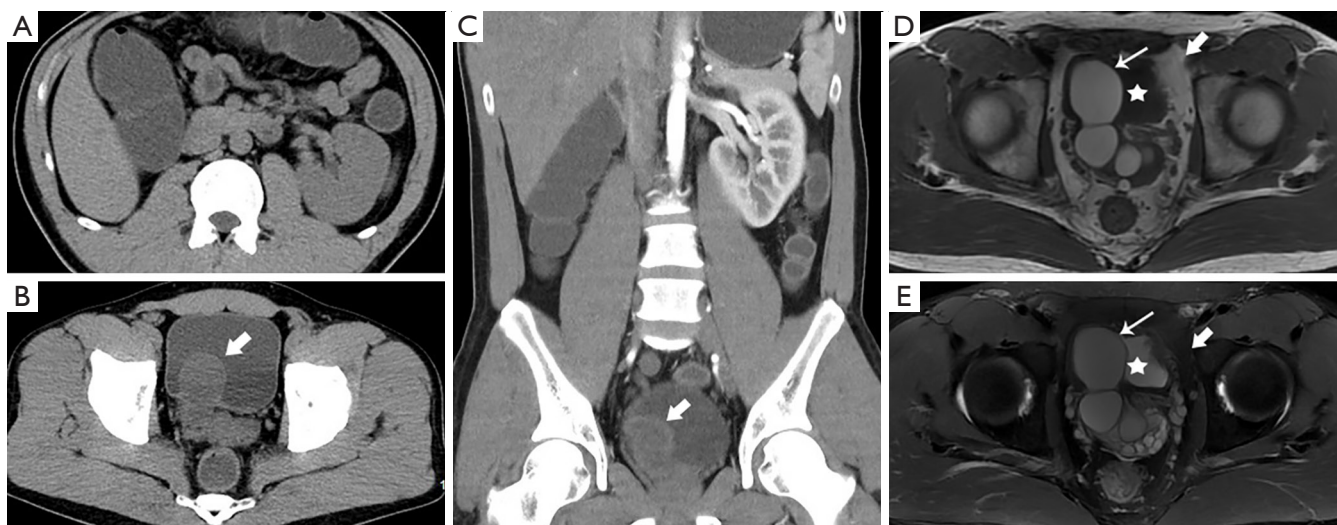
In a 30-year-old man with lower abdominal pain, CT presented the right renal agenesis (A) and posterior cystic lesions of the bladder (B,C, arrowheads). MRI showed the cystic lesions was attached to the right seminal vesicle and present as hyperintense in T1WI sequence and fat-suppression sequence (D,E) (short arrows) compared with bladder (stars) and fat (arrowheads). Operative and pathological findings as hemospermia in the seminal vesicle cyst. CT, computed tomography; MRI, magnetic resonance imaging.
